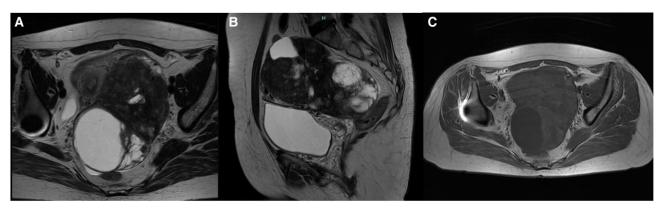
Magnetic resonance imaging results. A, T2-weighted sequence, axial plane, showing a heterogeneous pelvic mass displacing the uterus anteriorly and to the right. The mass exhibits a cystic component with multiple septations and a solid component. B, T2-weighted sequence, sagittal plane, showing a pelvic mass compressing the rectum posteriorly. C, T1-weighted sequence, axial plane, with no evidence of calcifications or macroscopic fat in the pelvic mass, ruling out the possibility of a teratoma.
